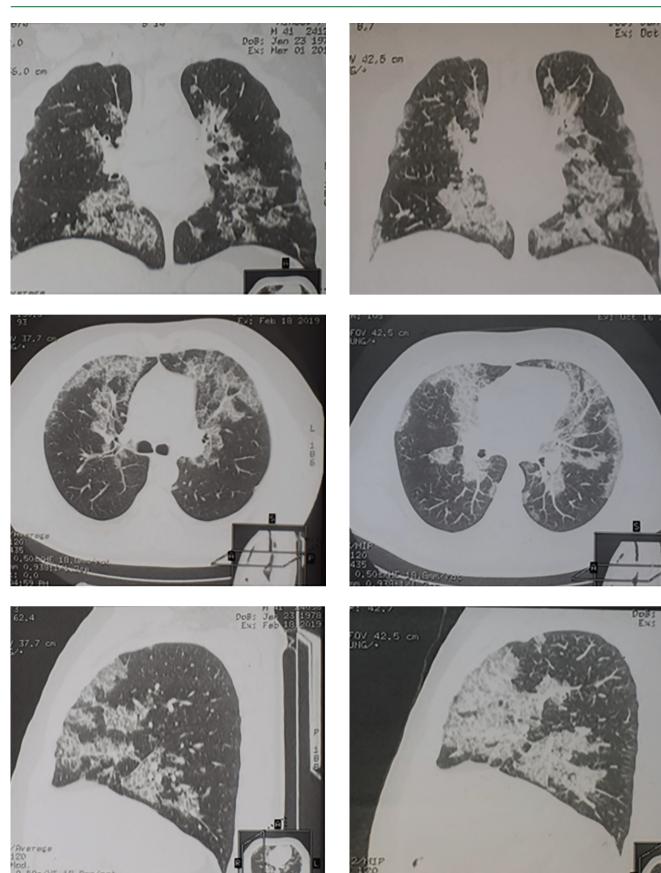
Computed tomography of TO, March, February 2019 (A), October 2019 (B). There are interstitial changes in the form of map-like ground-glass opacity across all lung fields.
